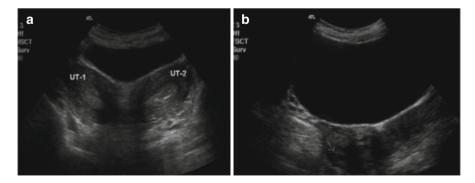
Double uterine abnormalities (double uterus, double cervix): abdominal ultrasound showing cross-sectional images of two uteri and cervices. (a) Double uterus. (b) Double cervix
